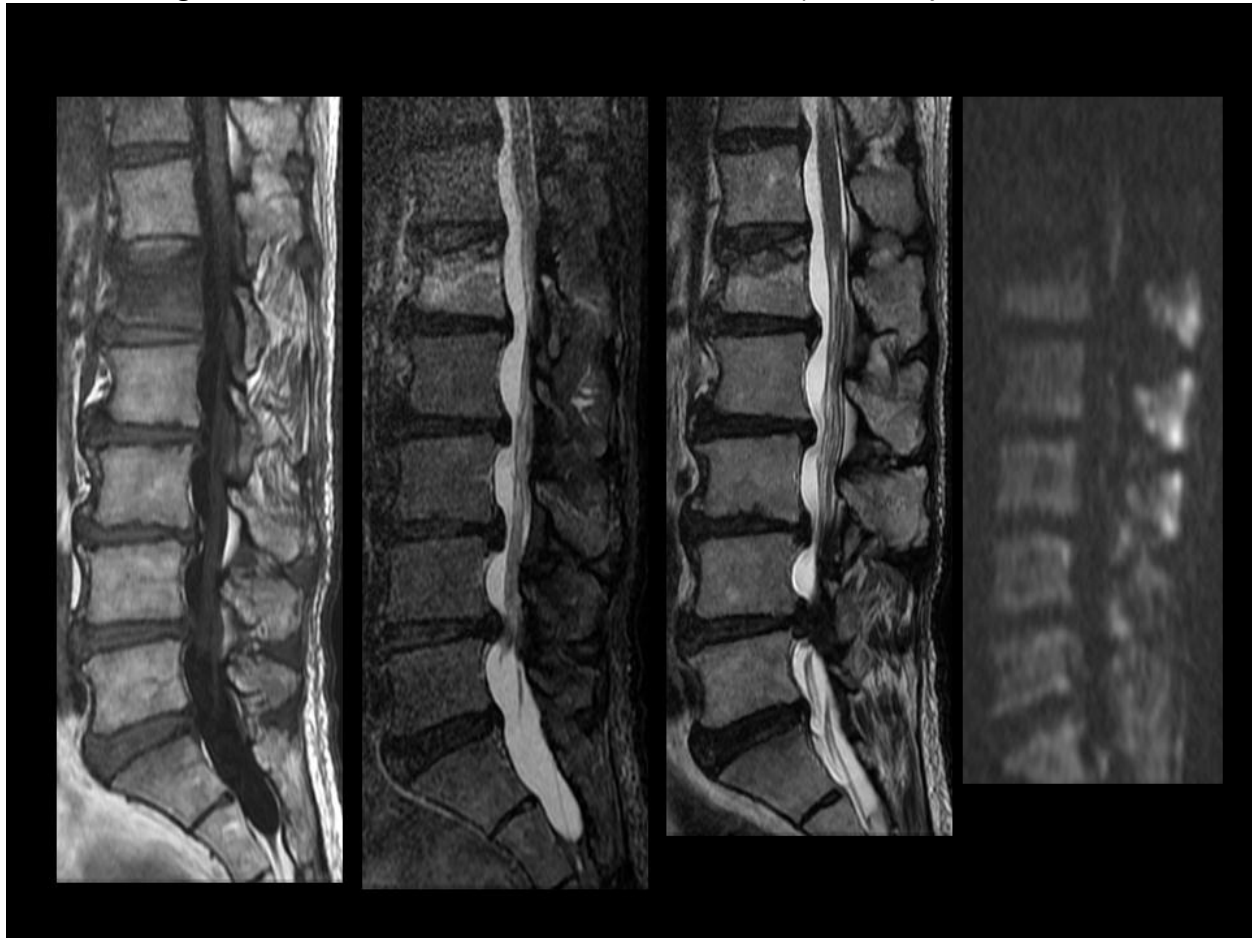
Senescent compression fracture. From left: T1 FLAIR, STIR, T2, DWI. Note the diminished signal on DWI associated with the recent compression fracture involving the superior end plate of L1.
